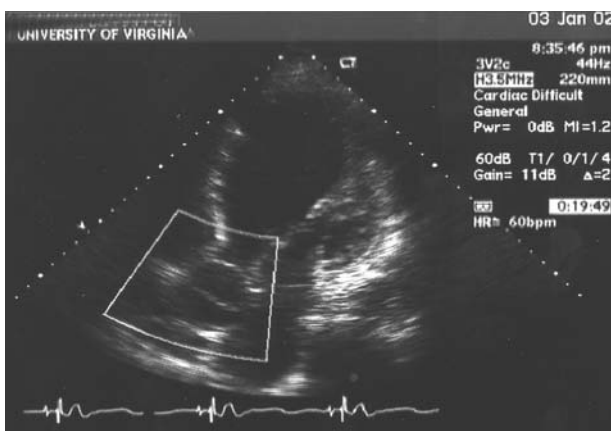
Transthoracic echocardiographic image of acute type A dissection. Occasionally a dissection flap is identified in the ascending aorta (inset) by using this comparatively insensitive imaging tool. If possible, the diagnosis of aortic dissection should be confirmed by an additional imaging study prior to initiating a particular management algorithm.
